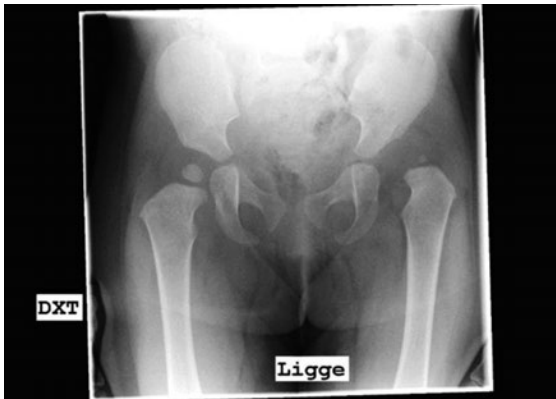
Anterior-posterior radiograph of pelvis. Unilateral hip dislocation. Dysplastic left acetabulum.
